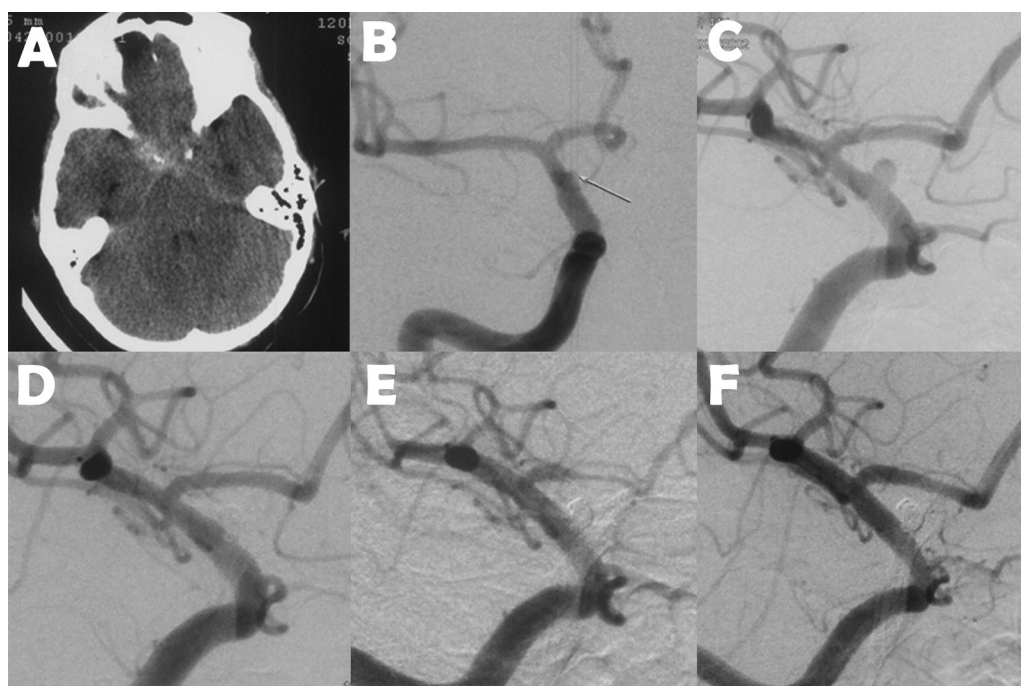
Radiography for case 13. A: CT scan revealed diffuse SAH; B: cerebral angiography at admission showed a wide neck tiny aneurysm at the C6 segment of the right ICA. The treatment was delayed because the patient suffered cardiac arrest. C: cerebral angiography 7 uneventful days later revealed apparent enlargement of the BBA. D: instant angiographic result with or without subtraction revealed total occlusion of the aneurysm. E: angiogram obtained at the 6th post-operative day for severe vasospasm confirmed the total occlusion of the BBA. F: angiographic follow-up at 3 m post-operatively revealed no contrast filling into the BBA.
